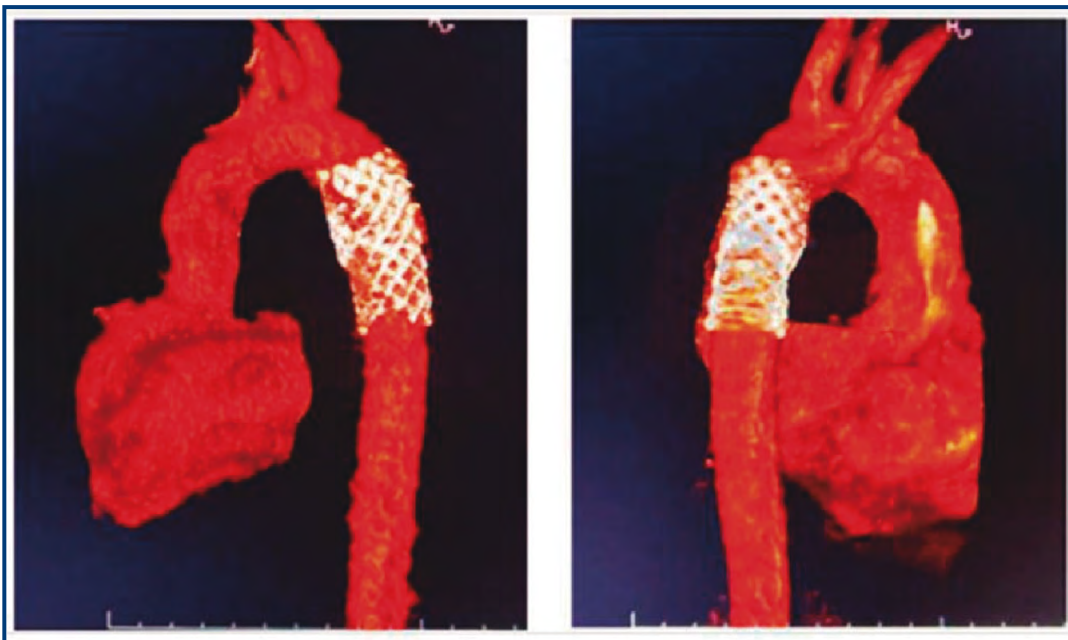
3D thoracic CT reconstruction showing stent, without contrast leakage to the pseudoaneurysm.
